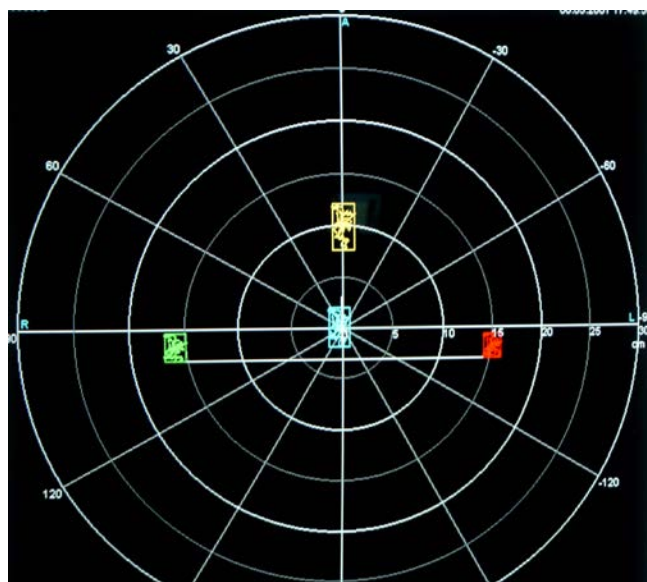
This ultrasound computer cranio-corpo-graphy (US-COMP-CCG) figure exhibits a standing test CCG of a 54-year-old male suffering from little vertigo. During 1 minute of standing, he exhibits a longitudinal sway of 4.46 cm, whereas the lateral sway only amounts to 2.32cm. The coverage of the frontal marker area only amounts to 10.32 cm<sup>2</sup>. There is a torticollis angle of only 1,12° to the left.
